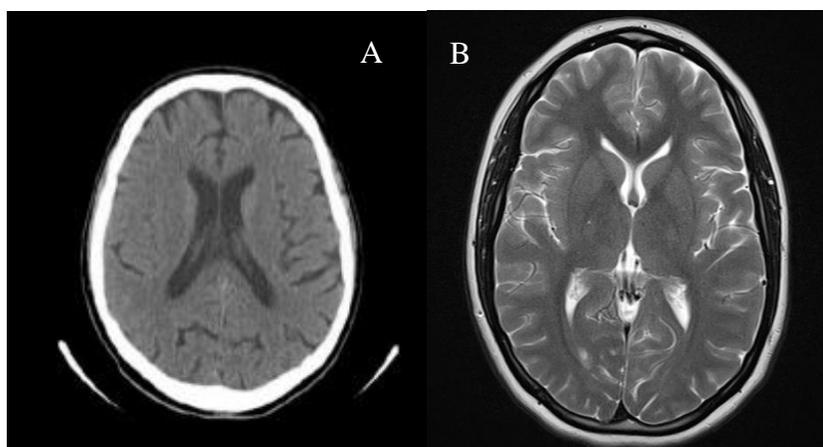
Images from A. computerized tomography (CT) and B. magnetic resonance imaging (MRI) head scan of the patient.
